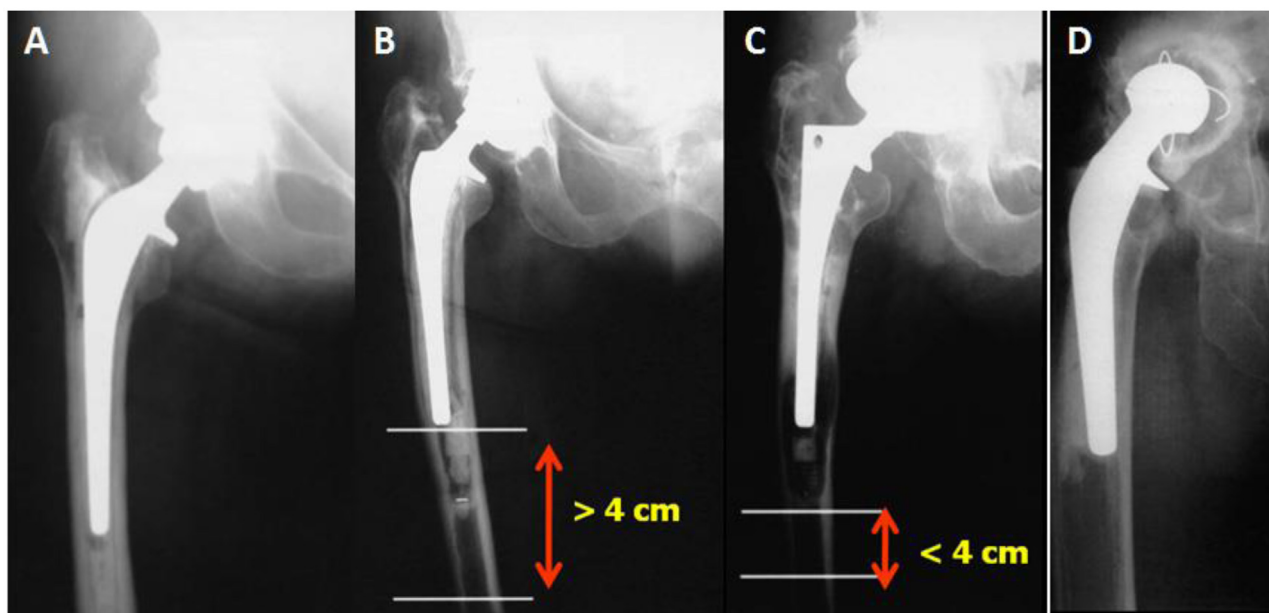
Radiographs showing aseptic loosening of femoral component arranged according to the Paprosky classification (A) Type II defect (B) Type IIIA defect (C) Type IIIB defect (D) Type IV defect.
